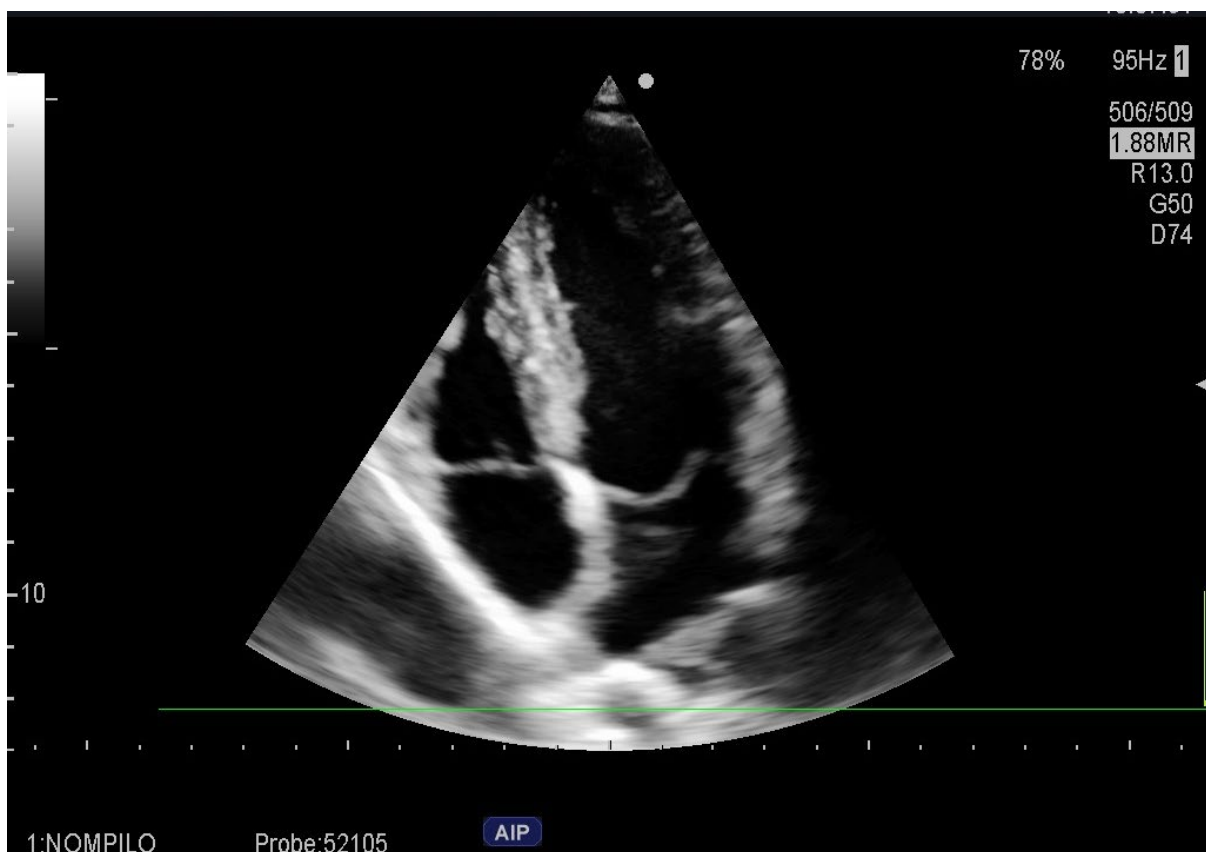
RV-focused apical 4-chamber.
